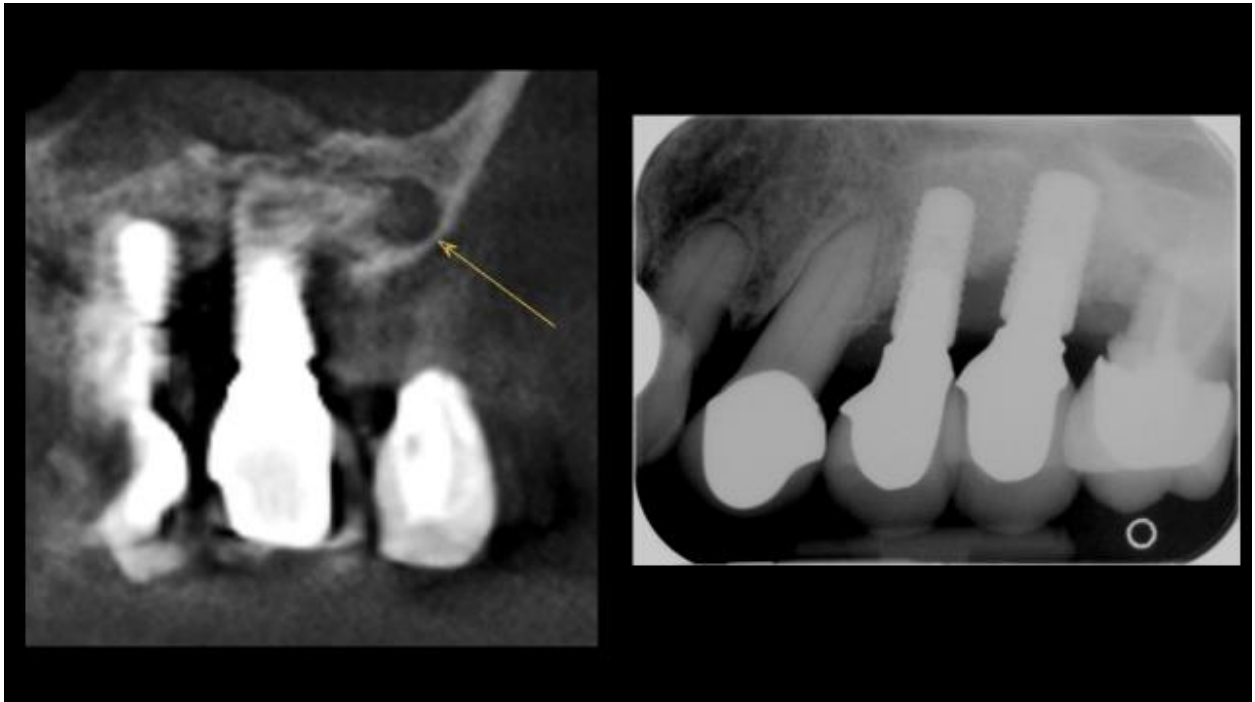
Residual Cyst CBCT (left) not visible on PA (right)
